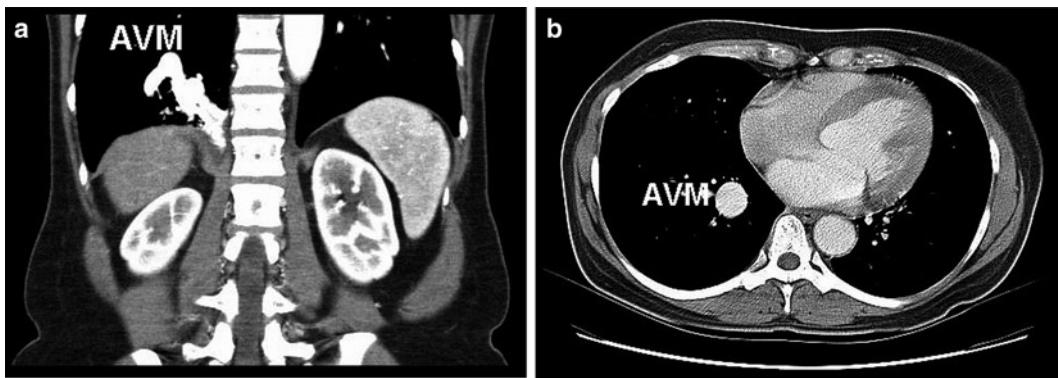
Contrast chest CT scans, (a) coronal, (b) transverse plane, of a patient with a right lower lobe pulmonary AVM who required right lower lobectomy.
